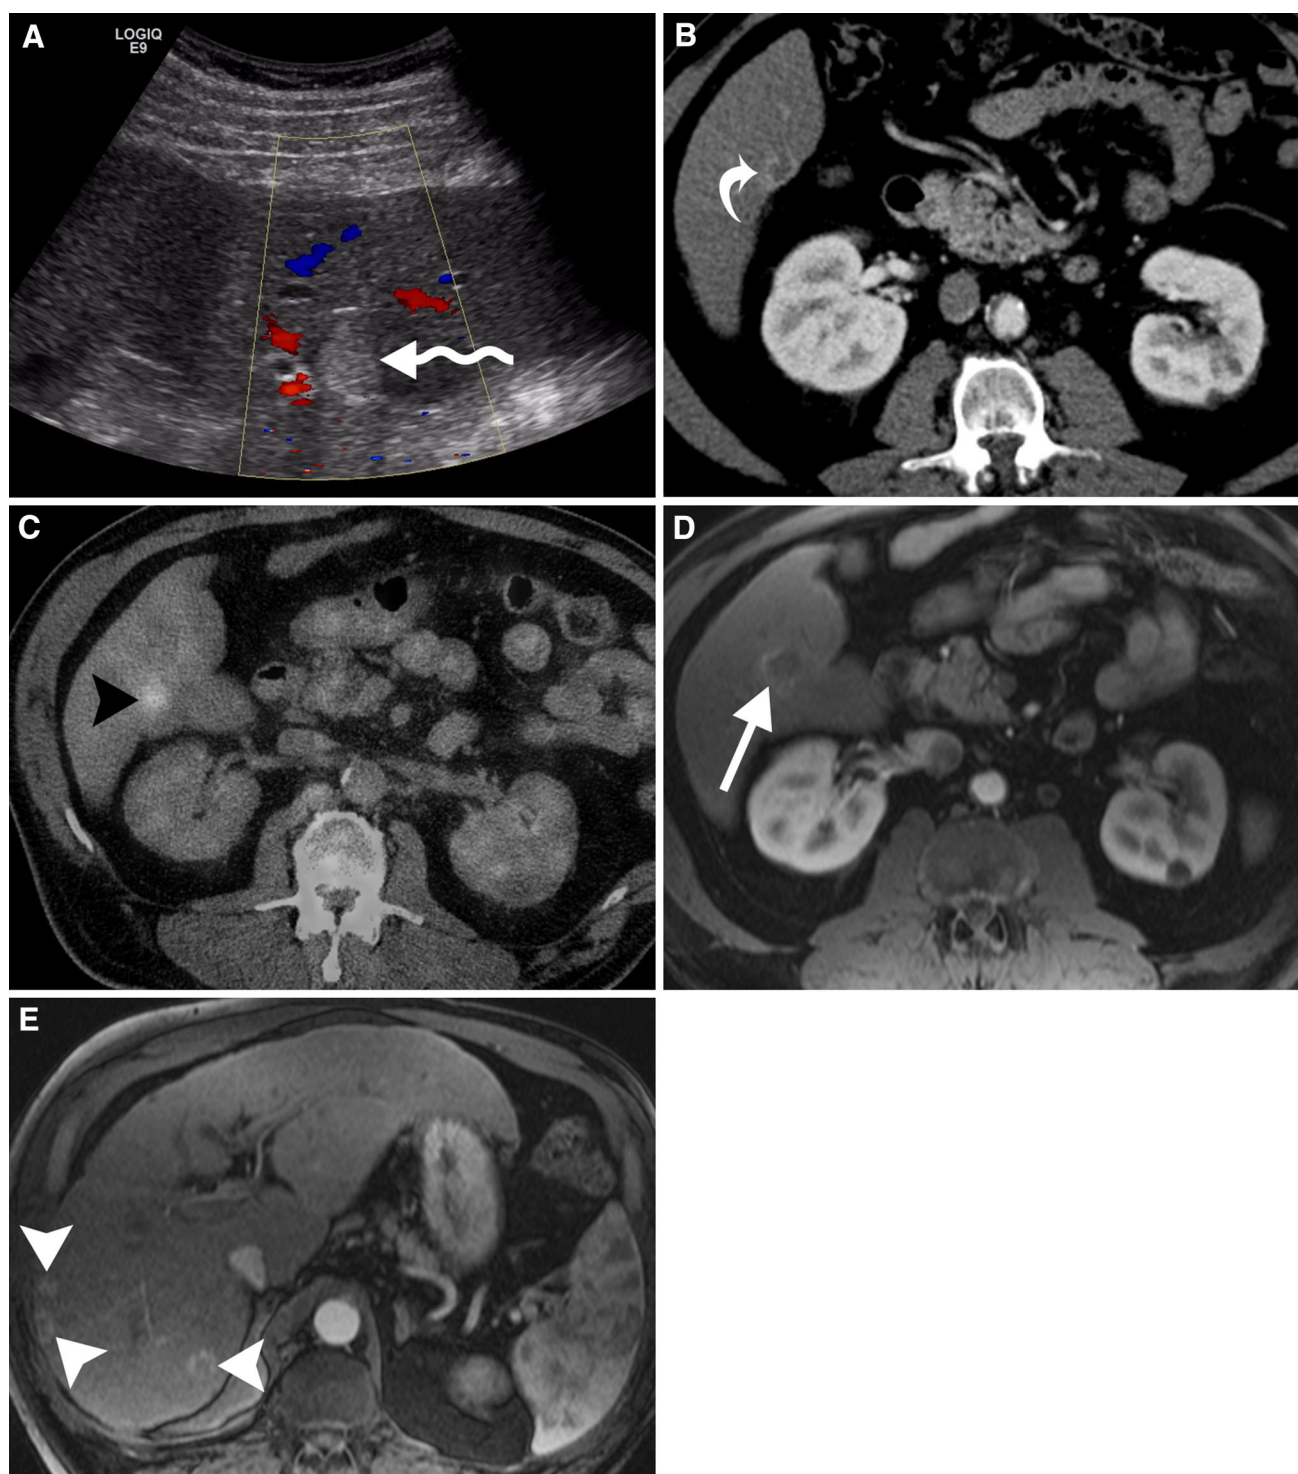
CHC in a 62-year-old man with hepatitis C and cirrhosis, with mixed imaging features. A Ultrasound demonstrates a hyperechoic liver mass without internal Doppler flow (*squiggly white arrow*). B Axial arterial-phase-enhanced CT demonstrates a peripherally enhancing segment 6 lesion (*curved white arrow*). C Axial-fused PET-CT demonstrates
